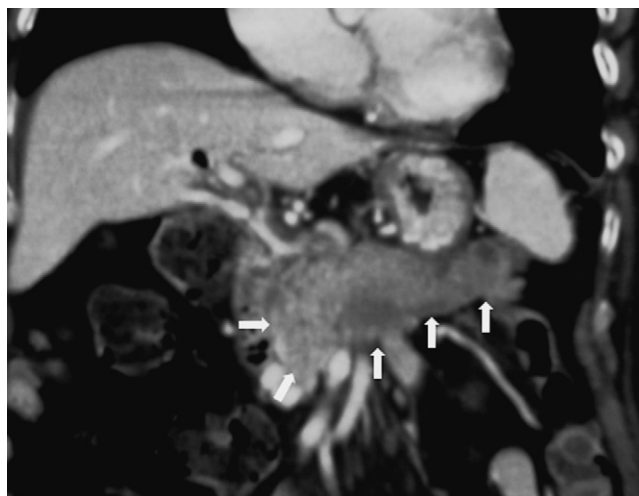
AIP, diffuse form. Contrast-enhanced CT shows the diffuse pancreatic swelling (arrows).
